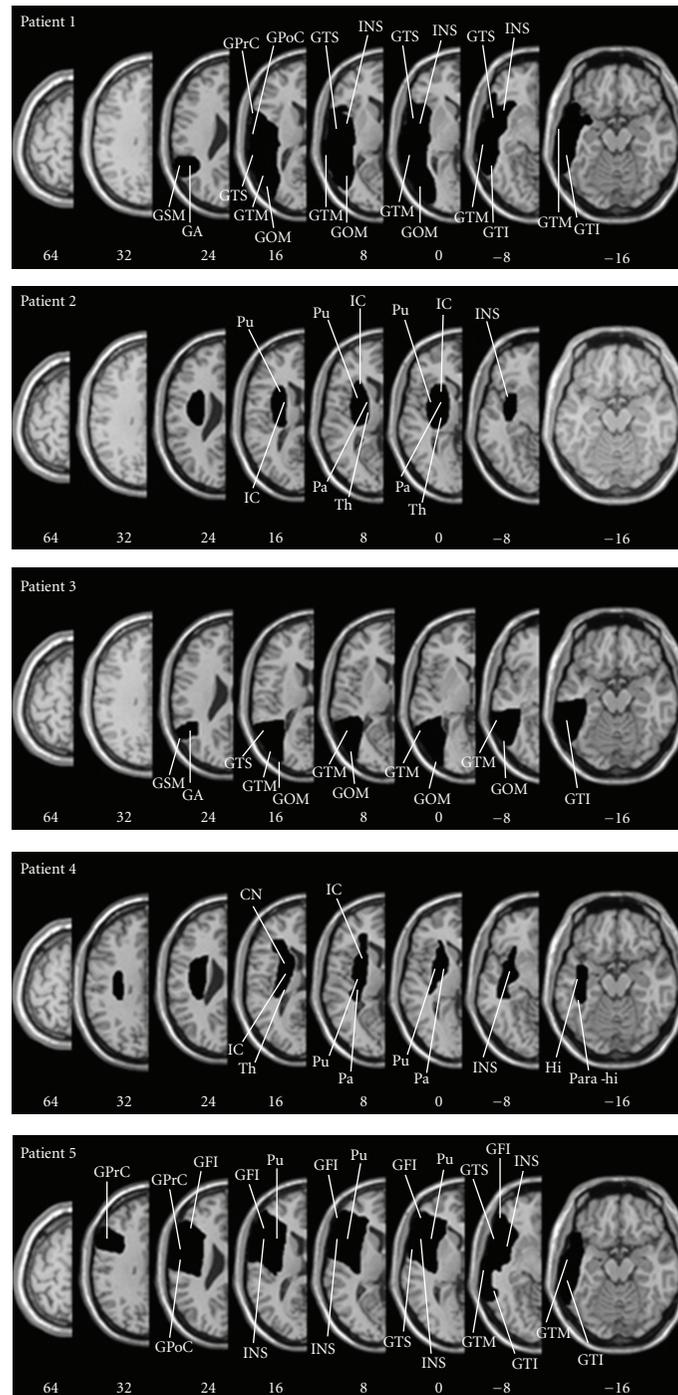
Lesion anatomy. For each patient, all lesions were mapped using the free MRICro software and were drawn manually on slices of the high-resolution 3D T1-weighted template MRI scan. This template is oriented to match the Talairach space. Lesions were mapped onto the horizontal slices that correspond to Z-coordinates  $-16$ ,  $-8$ ,  $0$ ,  $8$ ,  $16$ ,  $24$ ,  $32$ ,  $64$  in the Talairach space by using the identical or the closest matching horizontal slices of each individual. Following radiological convention, the right cerebral hemisphere is displayed on the left side. *Abbreviations:* CN, caudate nucleus; GFI, gyrus frontalis inferior; GOM, gyrus occipitalis medius; GPrC, gyrus precentralis; GPoC, gyrus postcentralis; GTM, Gyrus temporalis medius; GTI, gyrus temporalis inferior, GTS, gyrus temporalis superior; Hi, hippocampus; IC, internal capsule; Pa, pallidum; Para-hi, parahippocampus; Pu, putamen; Th, thalamus; GSM, gyrus supra-marginalis; GA, gyrus angular.
